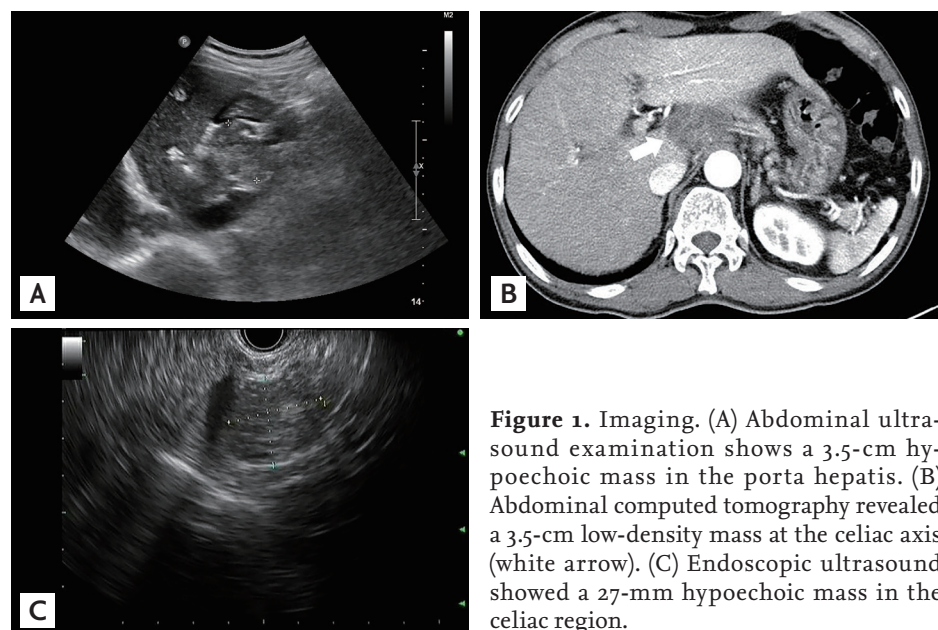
Imaging. (A) Abdominal ultrasound examination shows a 3.5-cm hypoechoic mass in the porta hepatis. (B) Abdominal computed tomography revealed a 3.5-cm low-density mass at the celiac axis (white arrow). (C) Endoscopic ultrasound showed a 27-mm hypoechoic mass in the celiac region.
